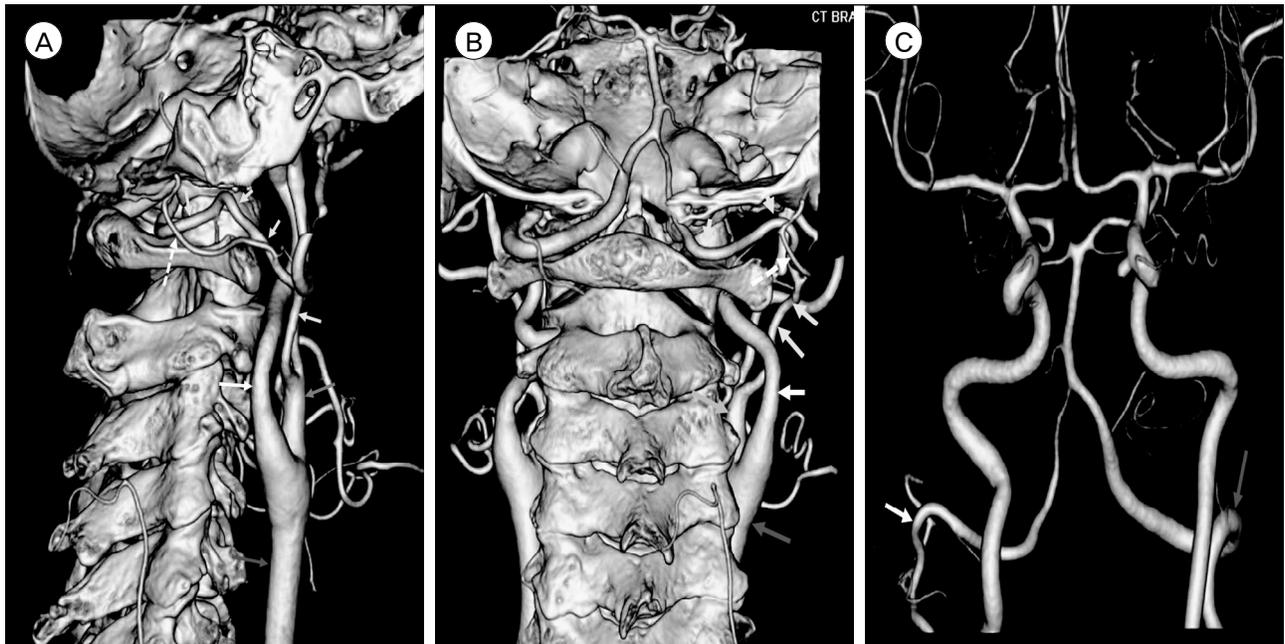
Computed tomography (CT) angiography (A, B) demonstrates a right persistent proatlantal artery originating from the right external carotid artery. This anomalous artery courses between the occiput and atlas but does not pass through the atlas transverse foramen (white dotted arrow, occipital artery; yellow arrow, proatlantal artery; blue arrow, external carotid artery; red arrow, common carotid artery; white arrow, internal carotid artery). Reconstructed CT angiography (C) shows the more lateral location of the right vertebral artery extracranial segment (white arrow) compared with the normal left vertebral artery (red arrow).
